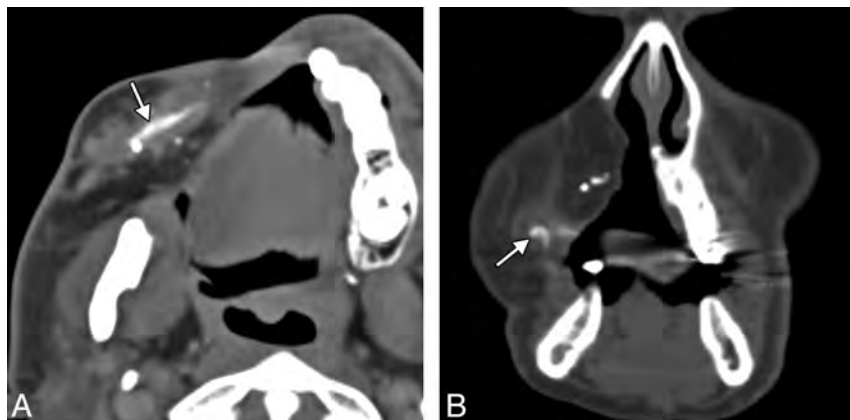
Gore-Tex sling. Axial (A) and coronal (B) CT images show the linear hyperattenuated strip of Gore-Tex that supports the right oral commissure (*arrows*). The patient is status post right complete maxillectomy with myocutaneous flap reconstruction.
